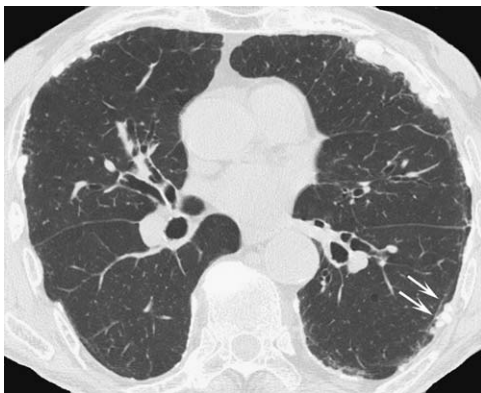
Subpleural line in a patient with asbestos exposure. Axial HRCT through the lower lobes shows a thin, curvilinear opacity in the left lower lobe (*arrows*), consistent with a subpleural line. Note presence of calcified pleural plaque, consistent with asbestos-related pleural disease.
